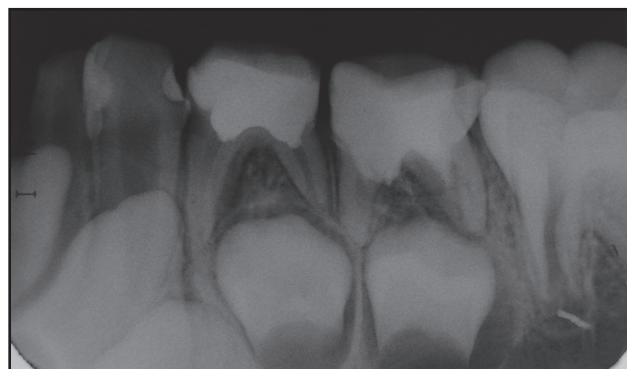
The 20-month follow-up radiograph showing bone formation at the furcation area and suggesting the healing of the underlying periodontal tissues.
